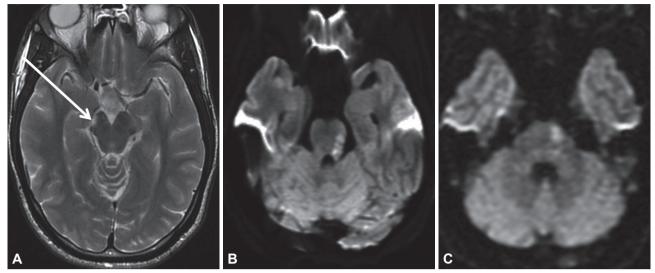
Axial brain MRI performed at different times in case 3. FLAIR sequence revealing a subacute right peduncular infarction (A, white arrow). DWI sequences showing acute ischemic infarctions involving predominantly the left superior cerebellar peduncle (B) and the left ventral pontine tegmentum (C).
